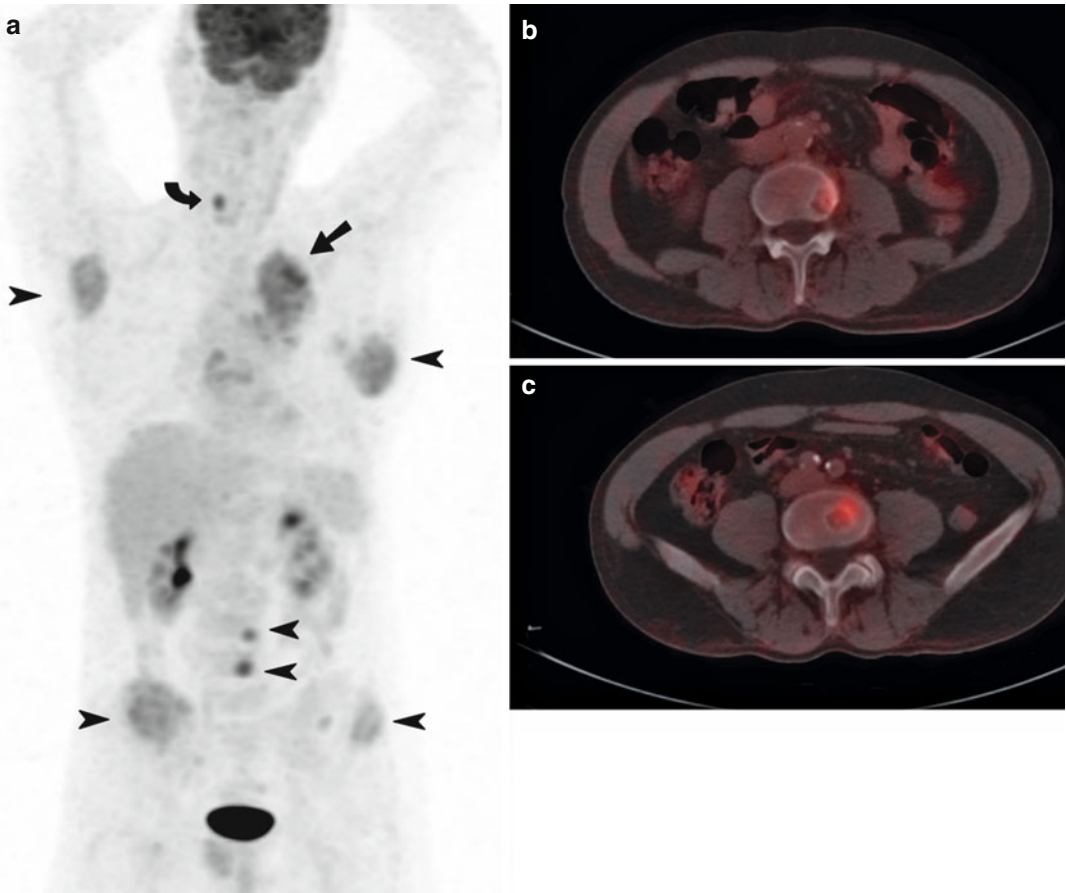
Staging non-small cell lung cancer. A 55-year-old man who presented with coughing, a hoarse voice and significant weight loss underwent a staging FDG PET-CT scan for newly diagnosed adenocarcinoma of the left lung. The patient was staged as T2N2M0 on conventional imaging, and the initial management plan was for radical treatment with a curative intent. On PET (a), the primary mass in the left upper lobe (*arrow*) demonstrated moderate FDG uptake ($SUV_{max} = 5.4$) with evidence of mediastinal invasion. There was also widespread metastatic disease within the bones (*arrowheads*) with extension into adjacent soft tissues in the scapulae and ilium. There was normal FDG accumulation in the brain, liver and testicles
